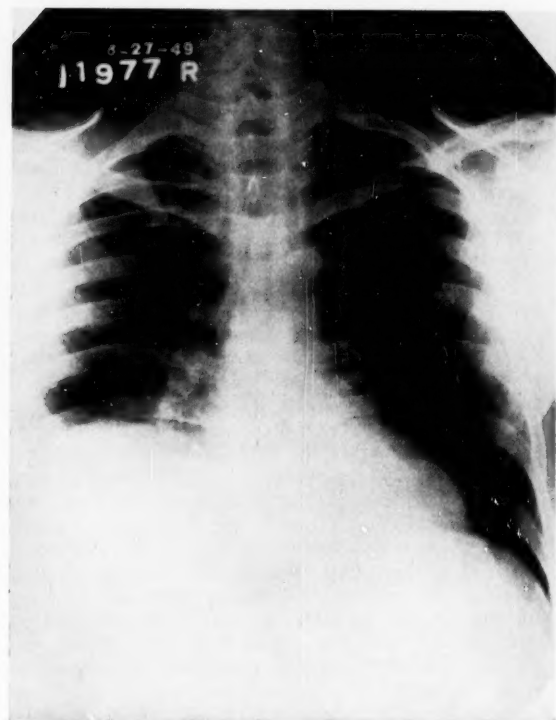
Chest x-ray of Case 5 (H. D.) showing elevation of right diaphragm. Fluid level below diaphragm is poorly reproduced in photograph.
